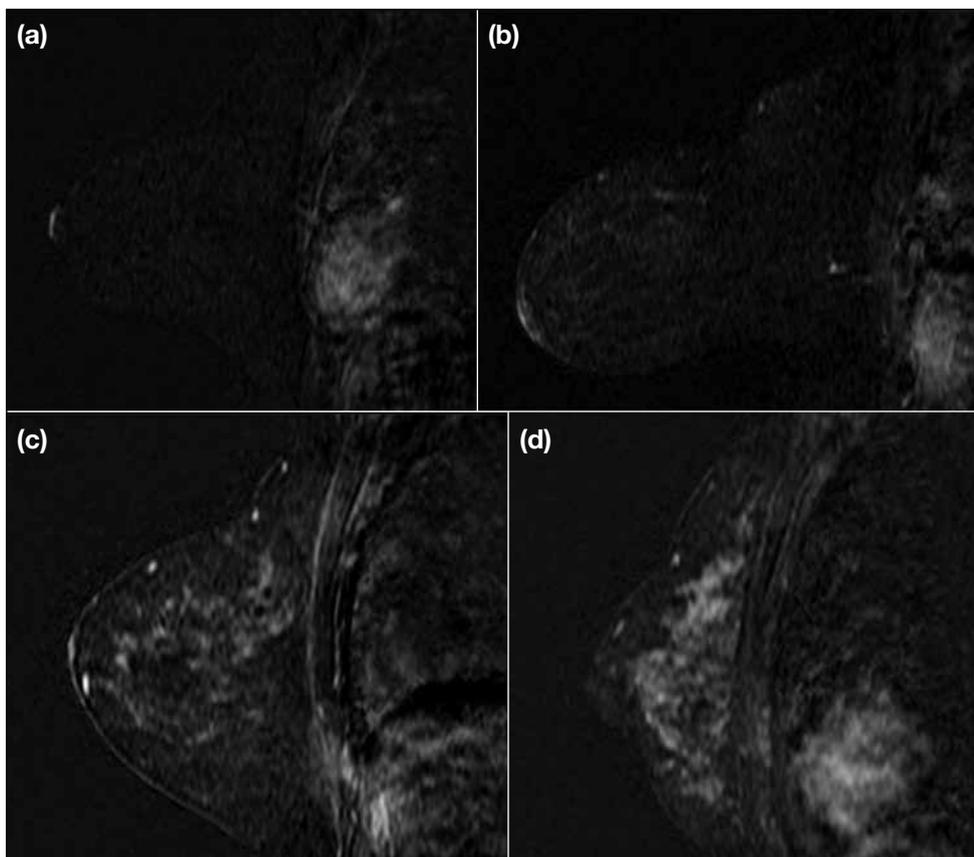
Sagittal contrast-enhanced T1-weighted fat-suppressed magnetic resonance images showing (a) minimal, (b) mild, (c) moderate, and (d) marked breast parenchymal enhancement.
